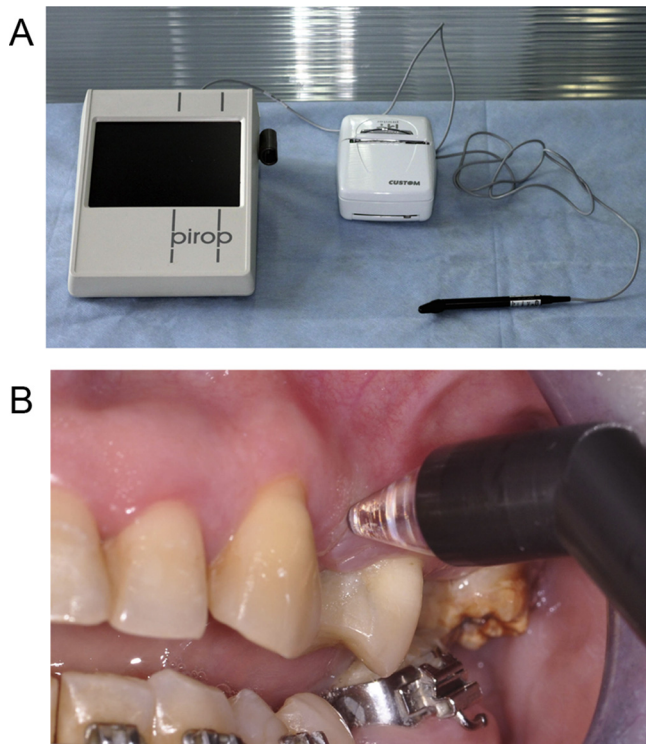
(a) Pirop[®] ultrasound equipment. (b) The measurement of keratinized gingiva in point 1 using Pirop[®] device.
